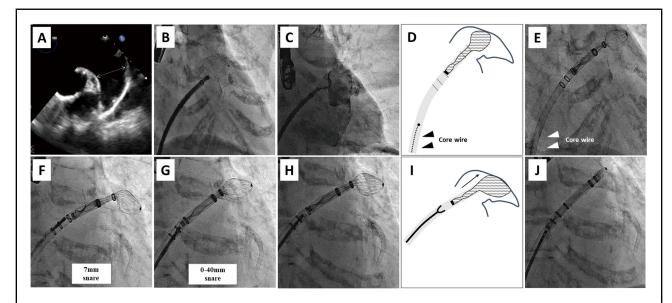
Retrieval of a disconnected WATCHMAN FLX device. (A) Transesophageal echocardiographic measurement of the left atrial appendage entry orifice. (B,C) Although percutaneous left atrial appendage closure was performed, the device was not deployed in an appropriate position. (D,E) After frequent recapture attempts, the disconnected device was located in the access sheath, despite making a "FLX ball". (F,G) Failure to grasp the device using 7- and 0–40-mm gooseneck snare catheters. (H–J) Successful retrieval of the device using an endomyocardial bioptome.
